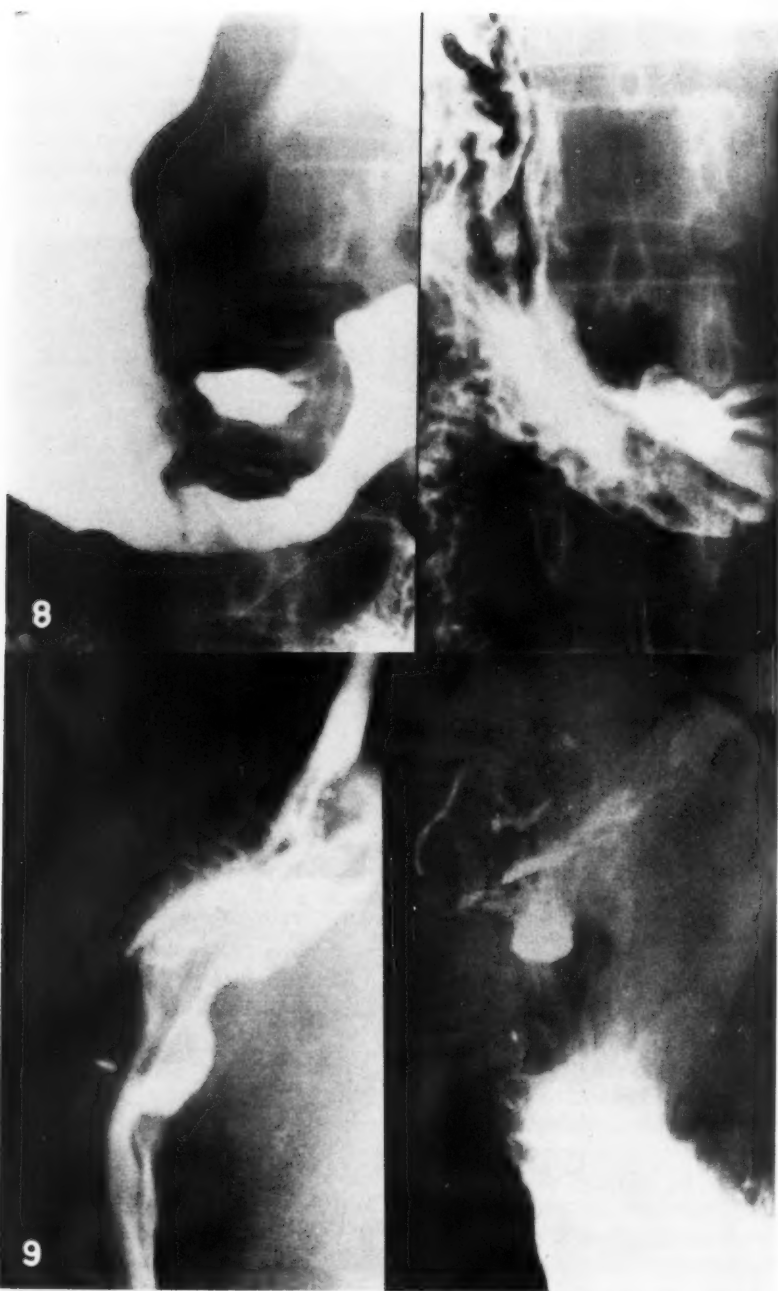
Gastric ulcer, indeterminate: F. P., 53-year-old female. Interpreted as either benign or malignant by x-ray. Cytology negative. Pre- and post-operative diagnosis benign. Surgical pathology demonstrated carcinoma.
